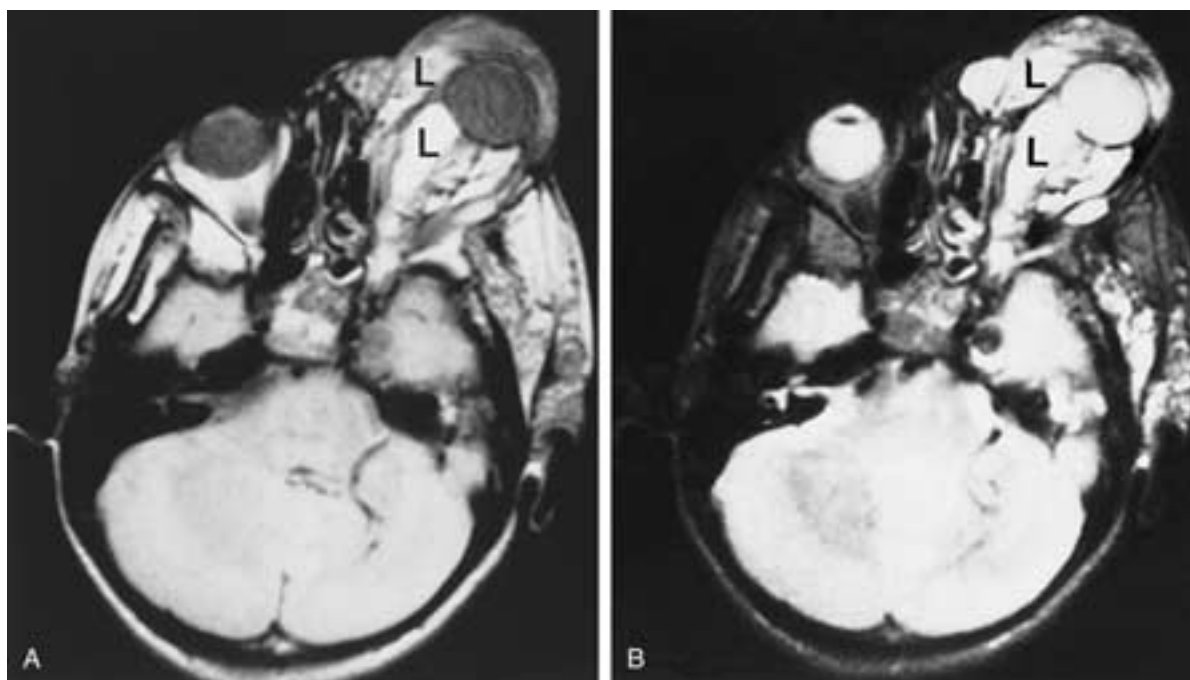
Lymphangioma. A, Axial PW MR scan. B, Axial T2-weighted MR scan. A and B show a large lymphangioma (L).
